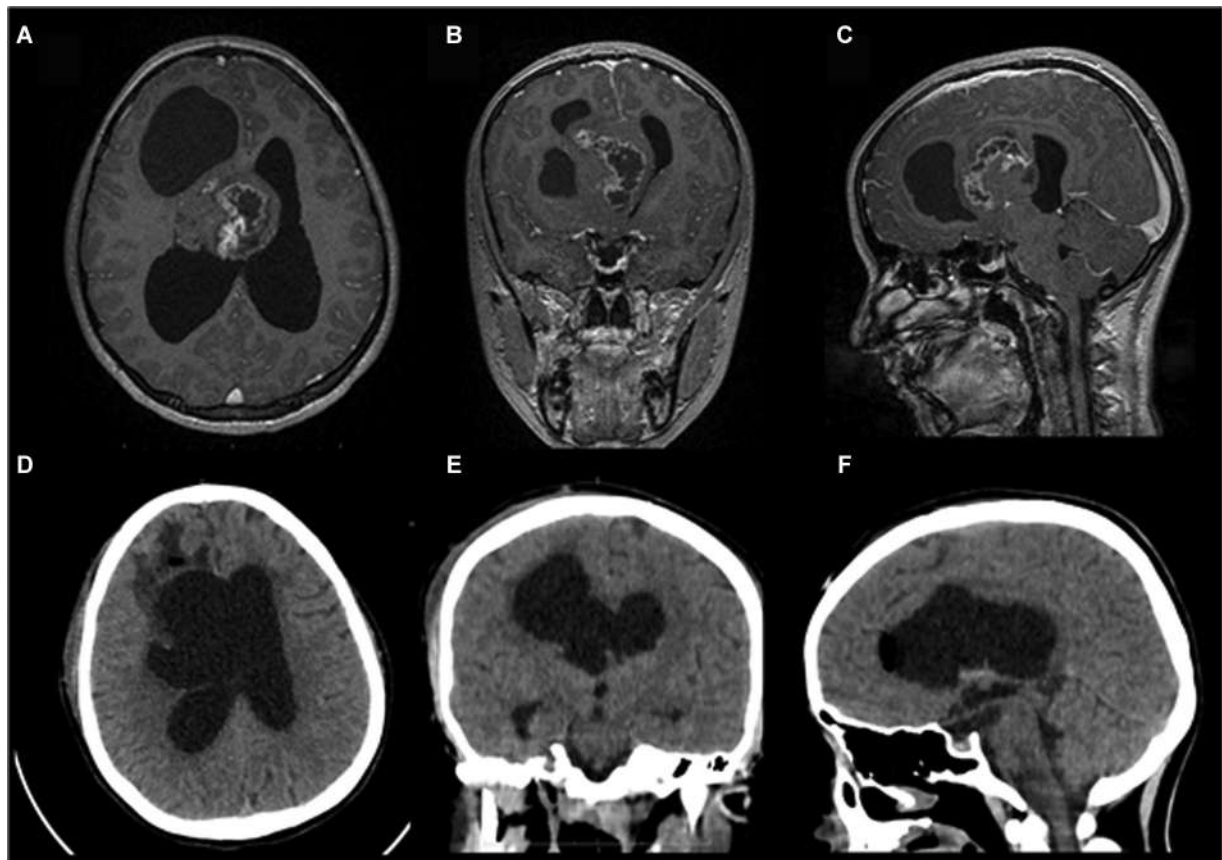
(A-C) Gadolinium-enhanced T1-weighted MRI scans in the axial, coronal, and sagittal sections showing preoperative pilocytic astrocytoma measuring $9.0 \times 6.4 \times 7.4$, extensively compromising the corpus callosum. (D-F) Postoperative brain CT showing gross total resection.
